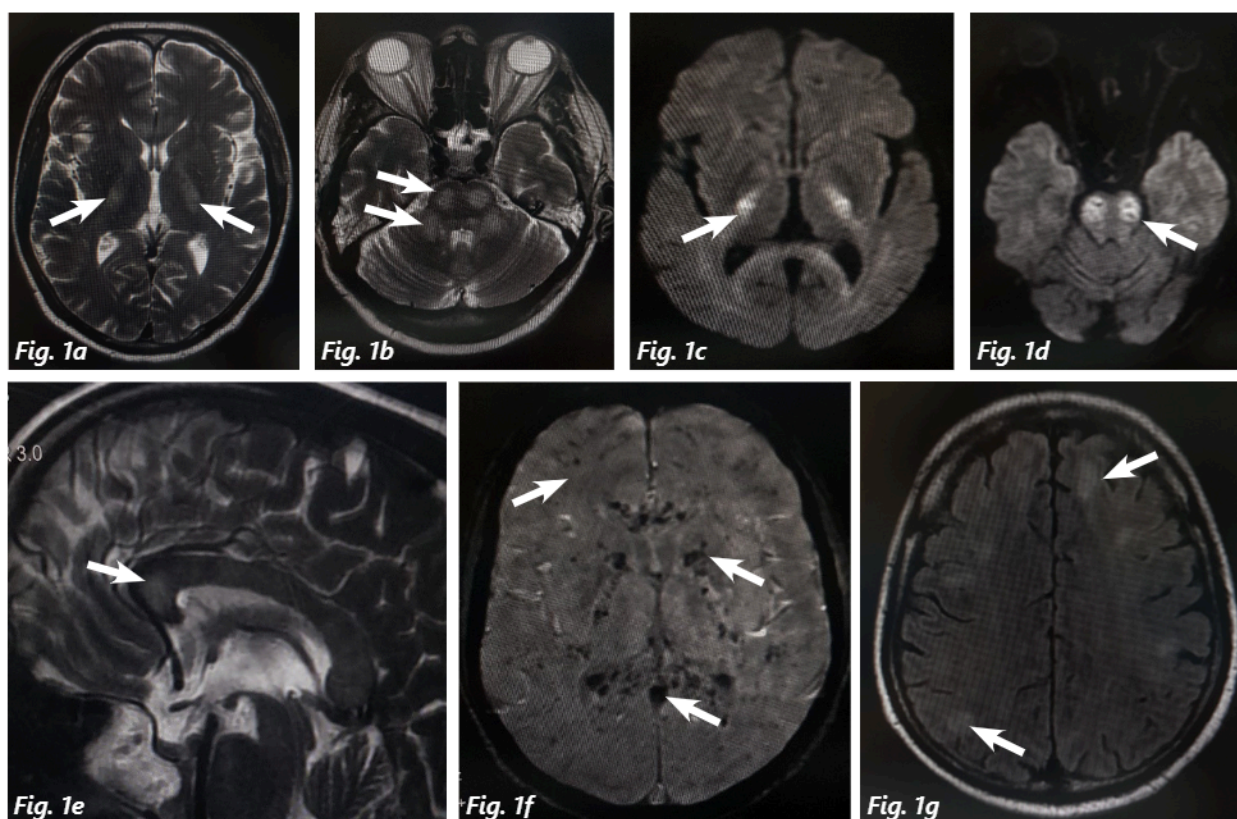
Axial T2WI shows high signal intensity within bilateral posterior limb of internal capsules (white arrows). Figure 1b. Axial T2WI shows high signal intensity within the pons in bilateral para-median location and middle cerebral peduncles (white arrows). Figure 1c. DWI shows high signal intensity within bilateral posterior limb of internal capsules (white arrows). Figure 1d. DWI shows restriction of diffusion within the pons in bilateral para-median location (white arrows). Figure 1e. Sagittal T2WI shows patchy high signal intensities within the corpus callosum (white arrows). Figure 1f. SWI shows signal drop outs/blooming in bilateral basal ganglia, corpus callosum and frontal lobes (white arrows). Figure 1g. Multiple FLAIR hyper-intense foci are seen in sub-cortical white matter of bilateral fronto-parietal lobes (white arrows).
